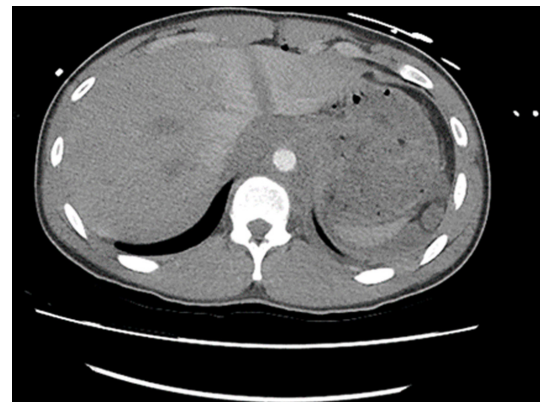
CT scan with liver laceration and peri-aortic hematoma.
